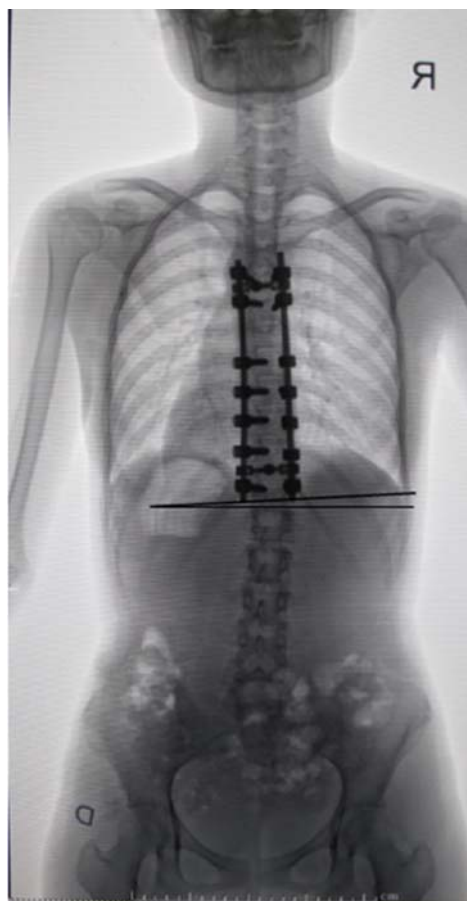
Measurement of the lower instrument vertebral tilt on the PA view of whole spine radiographs, measuring the angle between lower endplate of lower instrument vertebrae compared with a horizontal line
